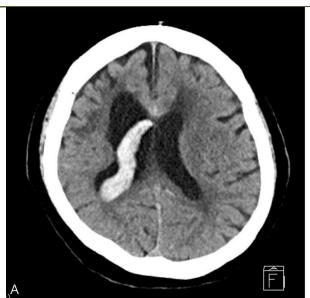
Serial brain CT images demonstrating stable intraventricular hemorrhage. (A) Pre-procedural CT (June 23, 2025) showing acute intraventricular hemorrhage in the right lateral ventricle in an asymptomatic patient. (B) Follow-up brain CT (June 25, approximately 20 hours post-procedure). CT, computed tomography
